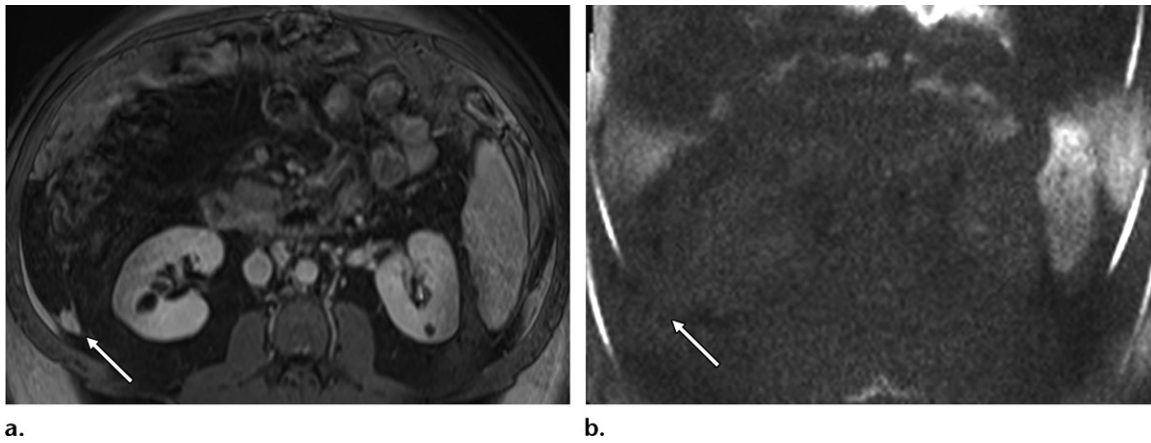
Missed peritoneal implants in a patient with multifocal HCC and a rising α -fetoprotein level. (a) Axial contrast-enhanced T1-weighted image with fat saturation shows a peritoneal implant in the right paracolic gutter (arrow), which was missed by the original interpreting radiologist. A different radiologist reviewing a subsequent imaging study identified the implants, which had grown in size. This radiologist reviewed the case with the radiologist who interpreted the prior imaging study, who noted that he used diffusion-weighted imaging (DWI) to evaluate for peritoneal disease. (b) On an axial high *b* value diffusion-weighted image, the multifocal HCC and peritoneal implants do not demonstrate restricted diffusion and are imperceptible (arrow).
